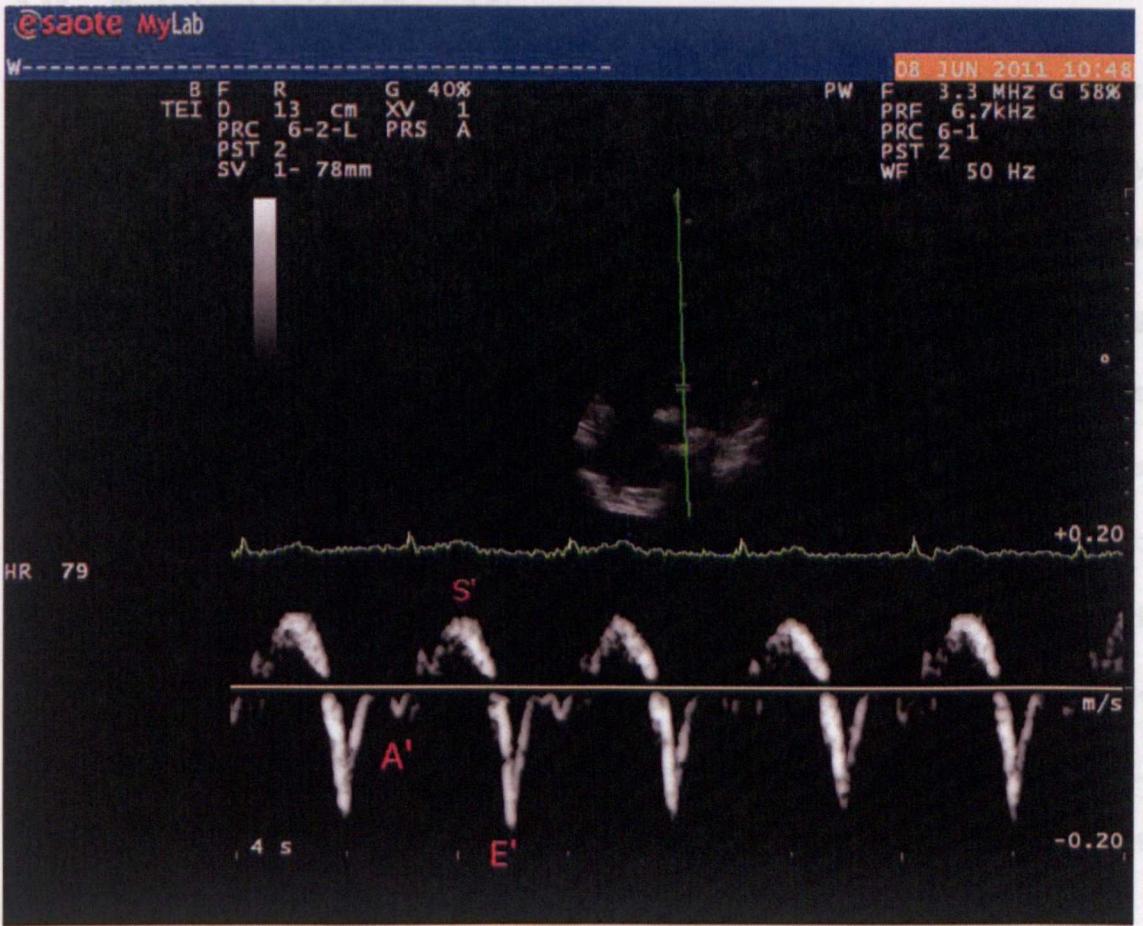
Tissue Doppler Image showing peak early diastolic (E') and late diastolic (A') and systolic (S') tissue velocity. Image taken from one of participant in Study 2.
